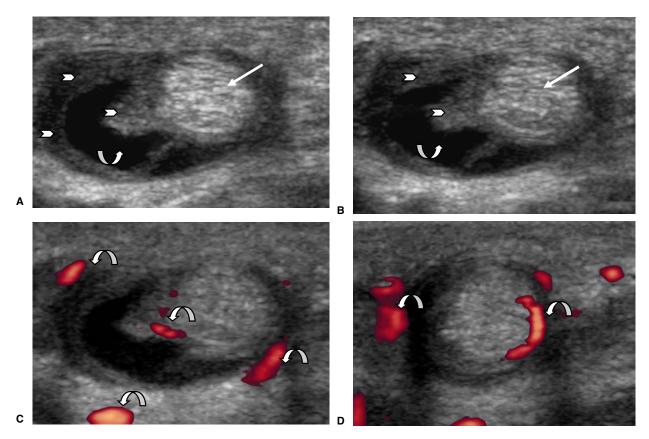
A, B Short axis, grayscale ultrasound images demonstrate enlargement and hypoechoic echotexture of the EPL tendon (straight arrows), reflecting tendinosis. There is surrounding tenosynovial fluid (curved up arrows) and synovitis (chevrons) within the tendon sheath, reflecting tenosynovitis. C, D Short-axis power Doppler ultrasound images demonstrate increased hyperemia within and surrounding the EPL tendon and tendon sheath (curved down arrows), reflecting acute inflammation.
